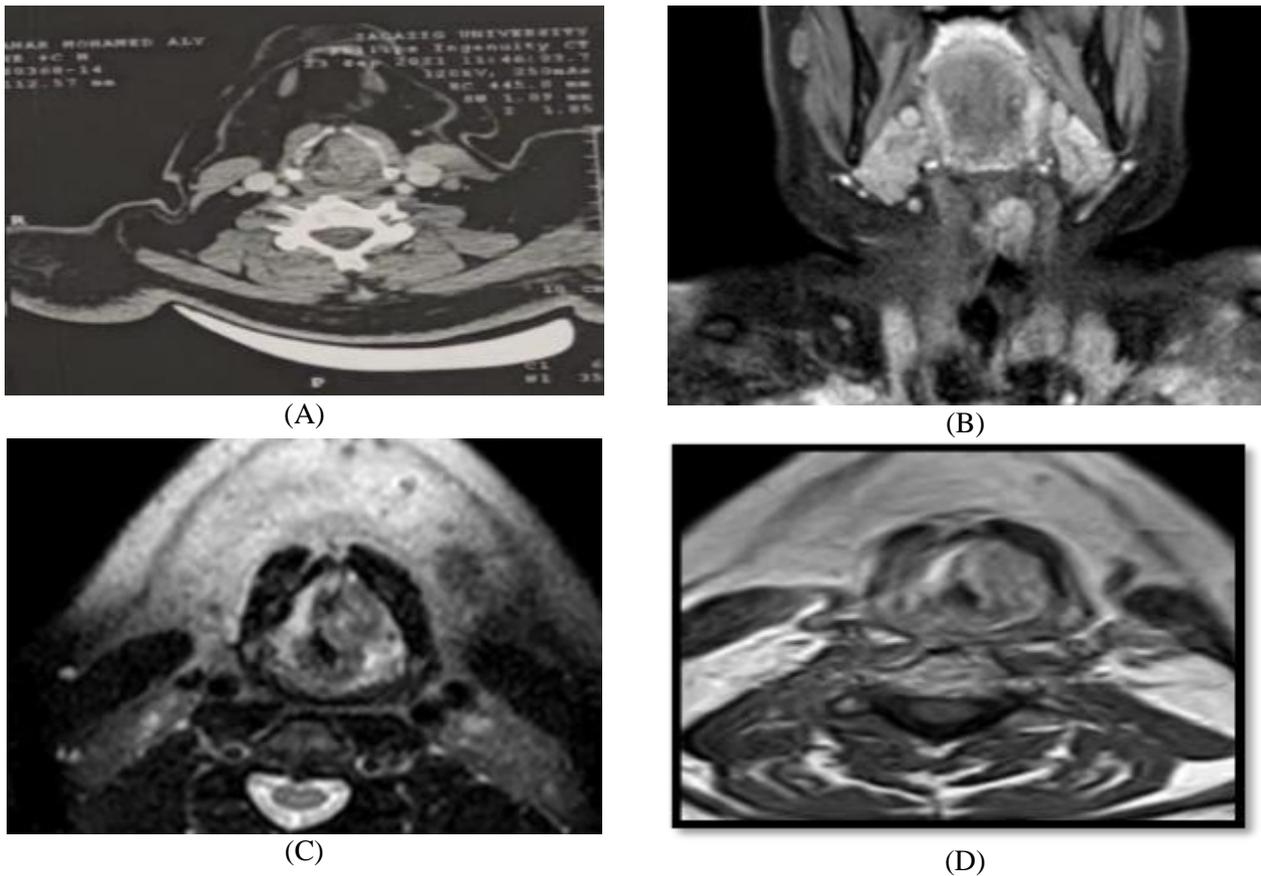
Male patient about 63 years old suffering from difficulty of swallowing and hoarseness of voice. (Glottic and supraglottic carcinoma). A) Axial CT showed ill-defined soft tissue mass in the glottic and supra glottic spaces at the left side with narrowing of the air way, No bony involvement or cartilage destruction, MRI: B) Coronal T1 showed ill-defined soft tissue mass in the glottic and supra glottic spaces at the left side with narrowing of the air way, C) Axial T2w showed ill-defined soft tissue mass in the glottic and supra glottic spaces at the left side with narrowing of the air way, D) Axial T1 W showed ill-defined soft tissue mass in the glottic and supra glottic spaces at the left side with narrowing of the air way.
